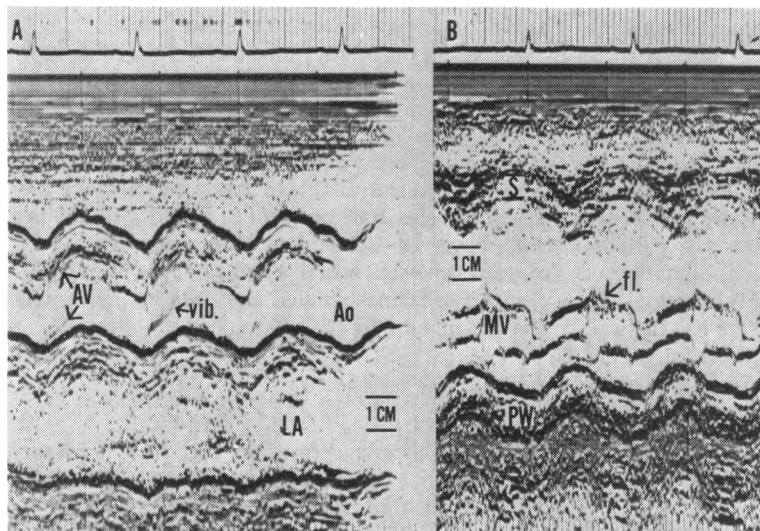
Patient with primary myxomatous degeneration of the aortic valve. (A) Echocardiogram of the aortic root (Ao), aortic valve (AV), and left atrium (LA). There is prominent high frequency vibration (vib) of the aortic leaflets. (B) Echocardiogram of the mitral valve and base of the left ventricle. The mitral valve (MV) shows diastolic fluttering (fl.) of aortic regurgitation. PW, posterior wall; S, septum.
